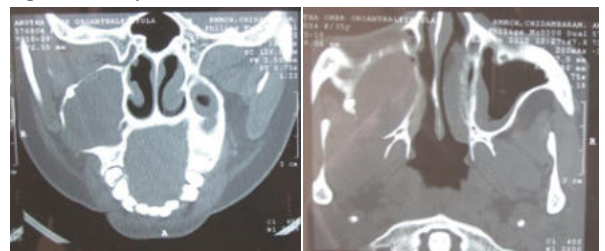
Axial & coronal section of CT reveals a hyperdense mass in maxillary antrum.
